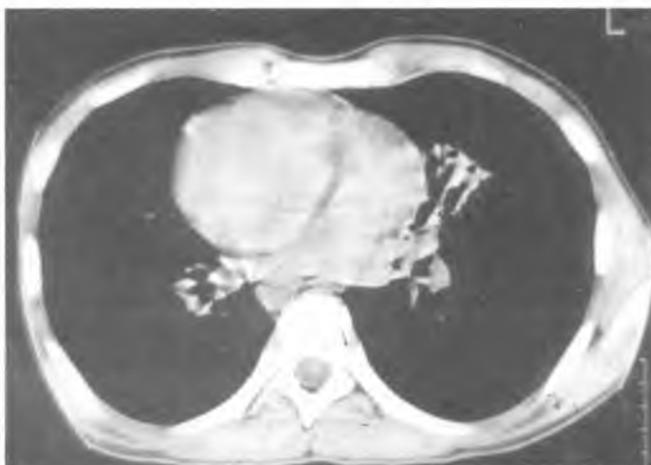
CT inflammatory-ectatic-cirrhotic changes within the middle lobe
